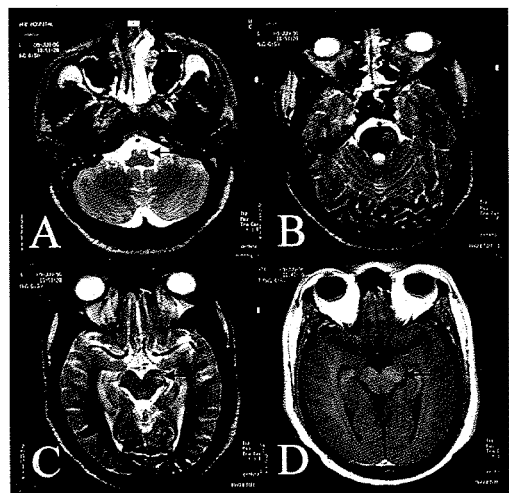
Initial intracranial magnetic resonance imaging. (A), (B) and (C) Axial T2 weighted turbo spin echo images show focal high signal extending from the right medulla to the right cerebral peduncle (arrows). (D) Axial T1 weighted post contrast image of the cerebral peduncles shows swelling of the right peduncle with only minimal enhancement (arrow).
